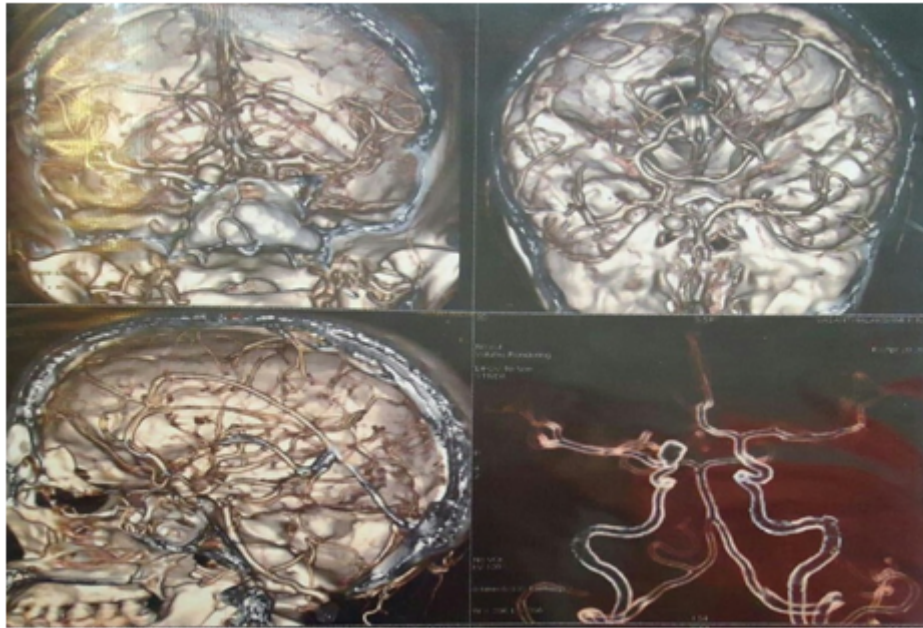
Computed Tomography Angiography (CTA) revealing a fairly well defined saccular aneurysm arising from Supraclinoid segment of Right ICA.
